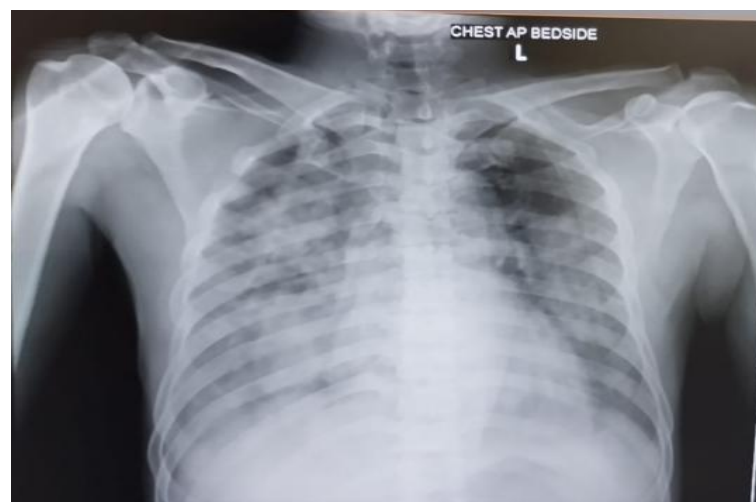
Bilateral Lung infiltrates (Chest X-ray AP View)
